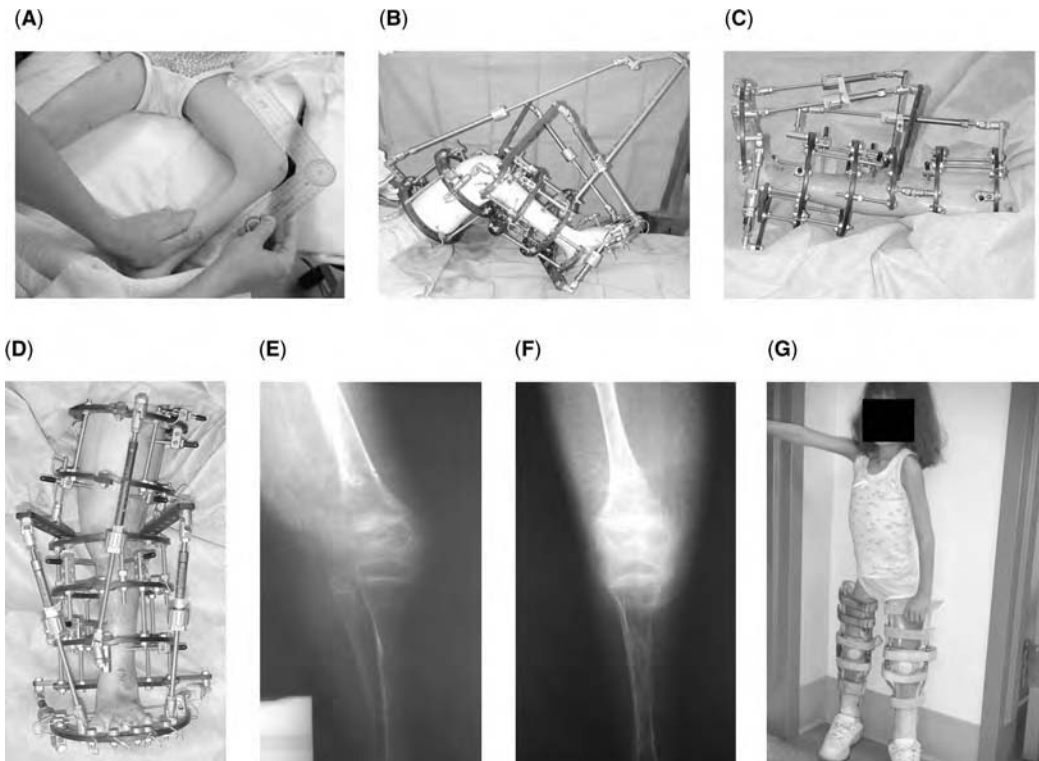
(A) Four-and-half-year-old girl with arthrogyposis, with bilateral 80° flexion contractures and clubfoot deformities. (B) Application of Ilizarov frame after posterior knee-release, and hind and midfoot osteotomies, for gradual correction of knee and foot deformities. (C) and (D) Side and front views on completion of correction. (E) and (F) Lateral and anteroposterior radiographs immediately after frame removal. The knee joint is still distracted. (G) At six years of age after correction of both knees.
